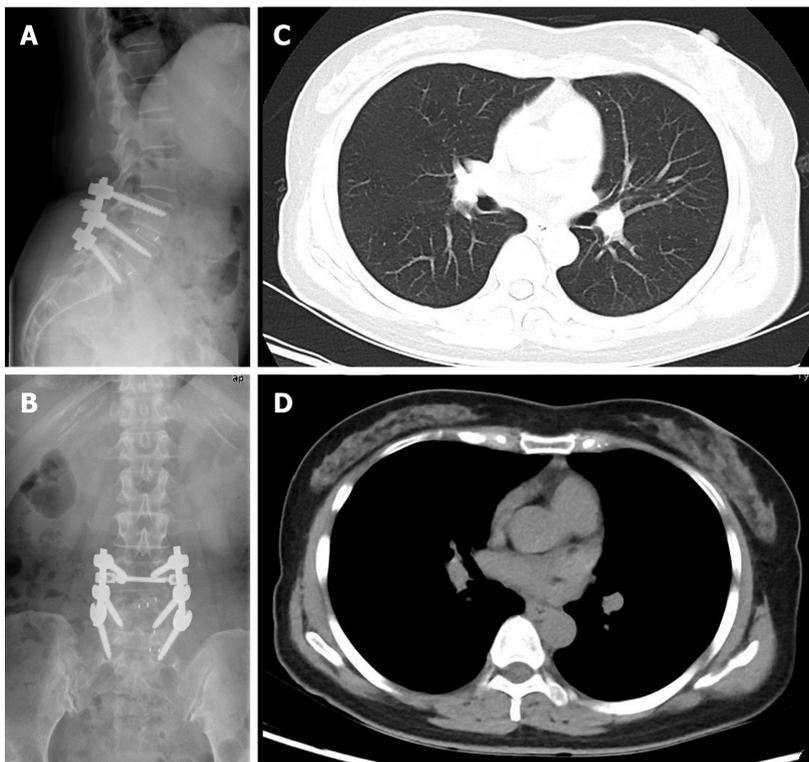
Postoperative follow-up radiographics. A and B: Reveal a successful lumbar surgery at the follow-up of postoperative 12 mo; C and D: Reveal a normal chest at the follow-up of postoperative 12 mo.
